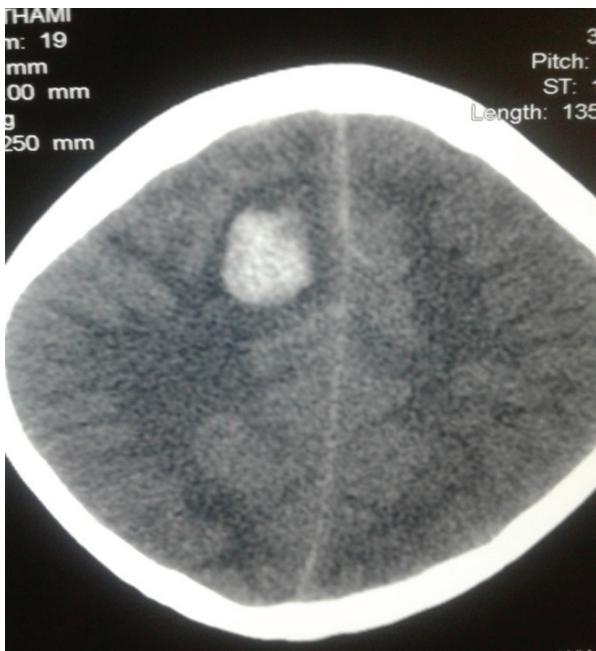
CT scan showing intracerebral haemorrhage in right frontal lobe
